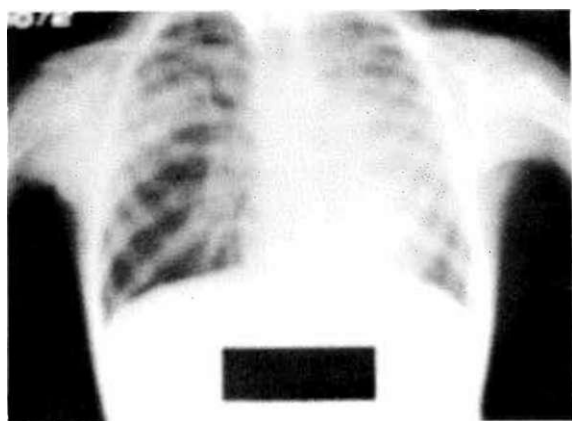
Chest X-ray after the removal of the foreign material which obstructed the left main bronchus.
